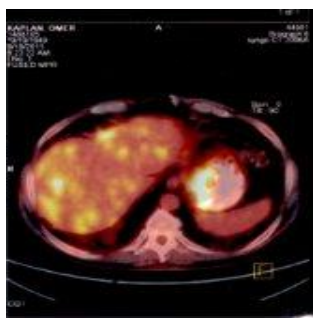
PET/CT image shows gastric mass and multiple hepatic metastases.
